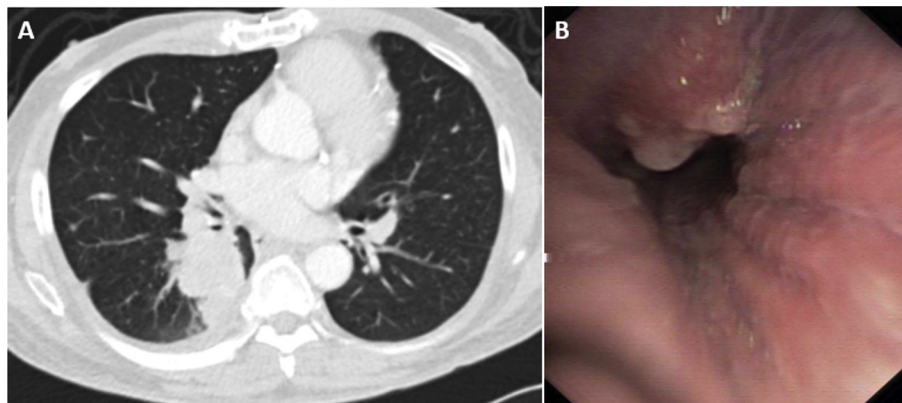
A) CT scan showing the mass in the right lower lobe with extrinsic compression of bronchus intermedius. B) Bronchoscopy image showing the endobronchial lesion in the bronchus intermedius at the 12 o' clock position.
